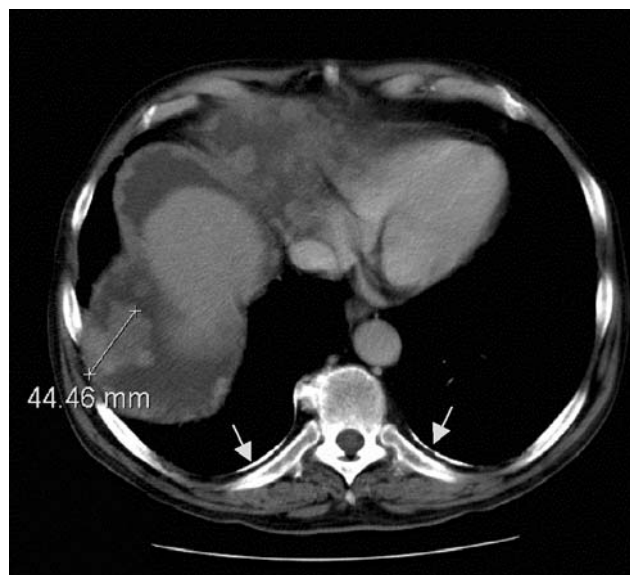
CT scan of the chest and abdomen demonstrated multiple peritoneal masses (maximal diameter 4.5 cm.) and bilateral calcified pleural plaques in the thoracic cavity (arrows).
